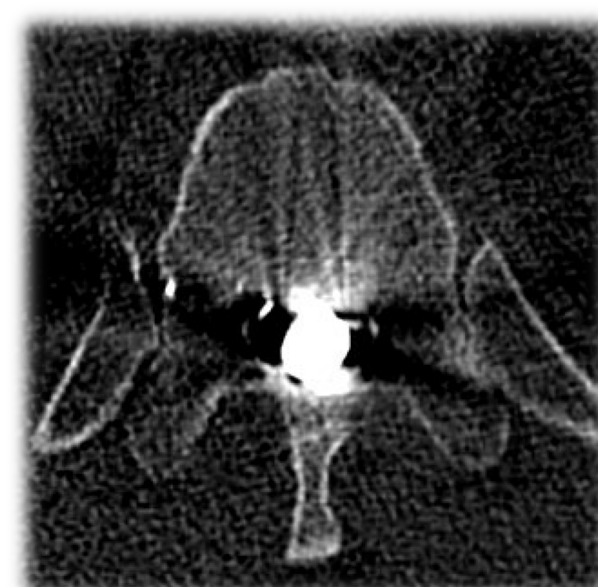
Transverse Thoracic spine CT imaging demonstrating a retained bullet within the spinal canal at the level T11.
